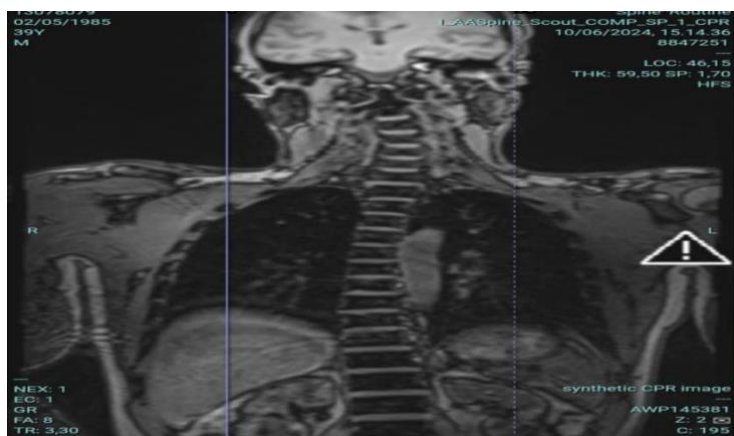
MRI angiography evaluation after 8 weeks after surgery no longer found stenosis in the left Subclavian vein.
